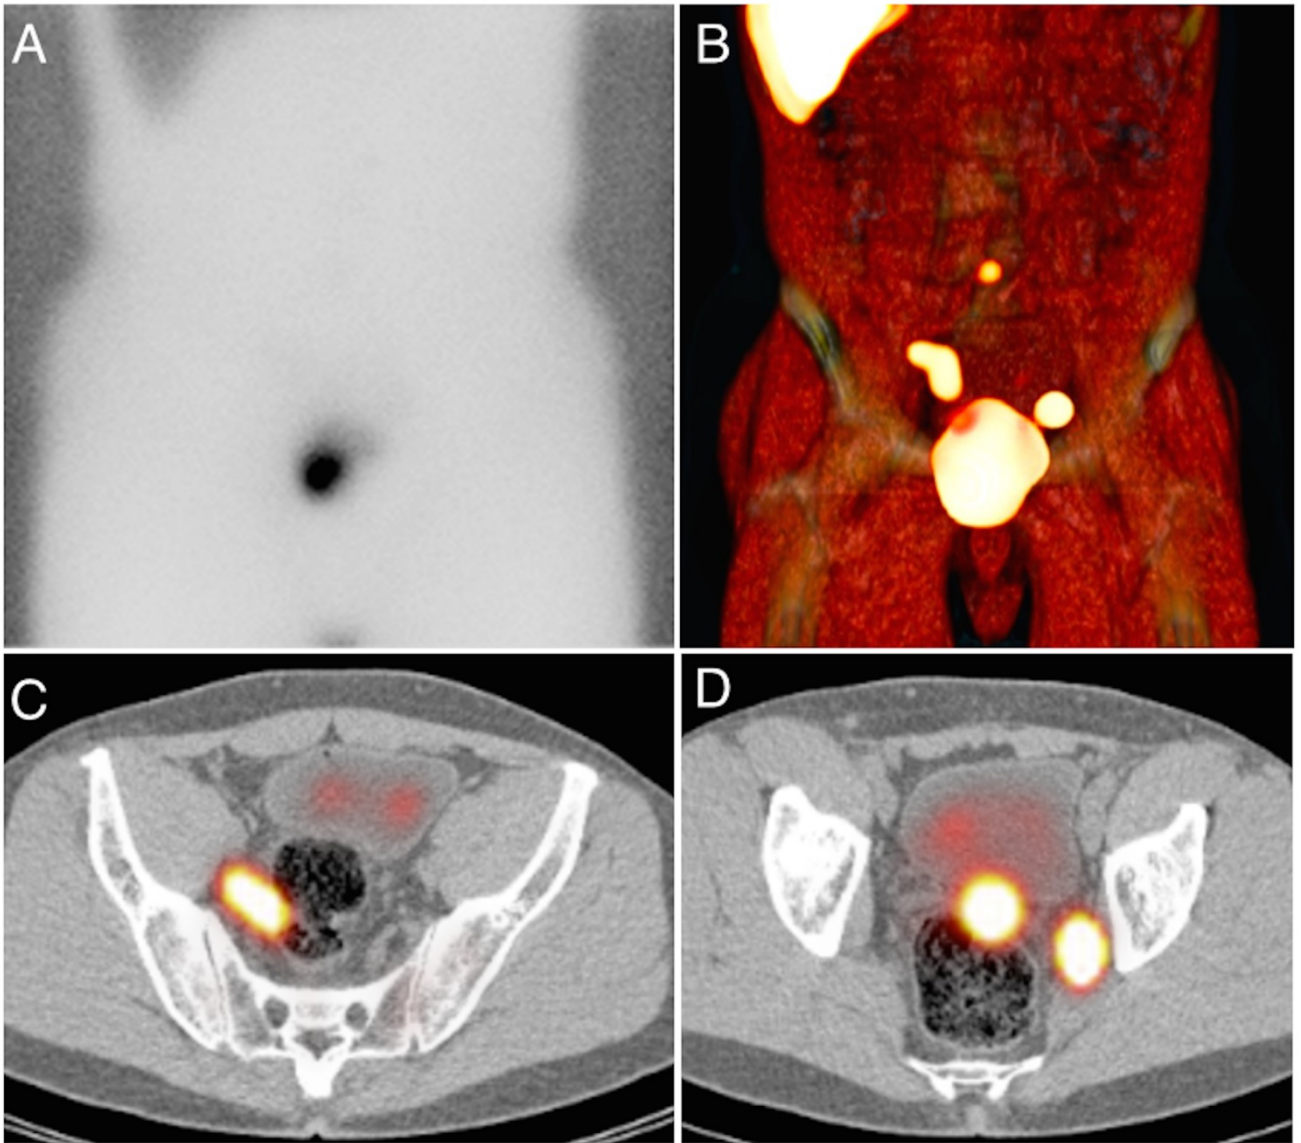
Patient with prostate cancer without evident lymphatic drainage on anterior planar image (A). SPECT/CT displayed with volume rendering (B) shows bilateral drainage to obturator lymph nodes in the pelvis and to a sub-aortic lymph node. The iliac sentinel nodes are seen as hot spots on transversal SPECT/CT fusion images (C, D).
